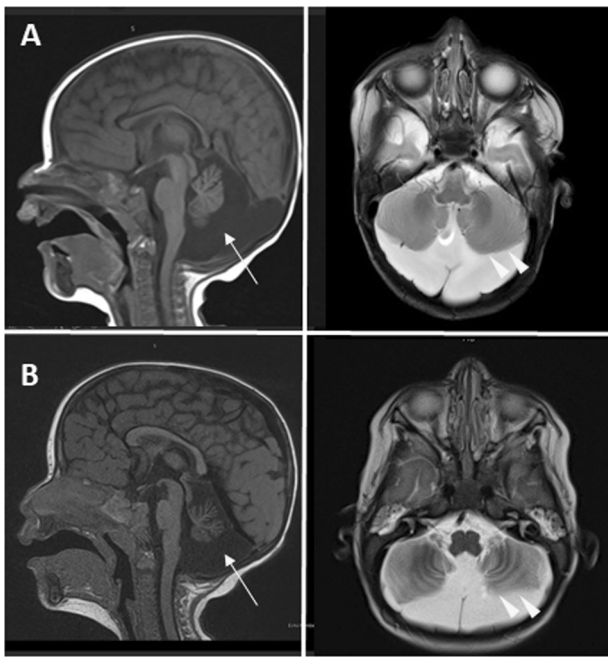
Brain magnetic resonance imaging (MRI) of affected individuals. Sagittal T1 and axial T2 views demonstrating enlarged CSF spaces, especially in the posterior fossa, with relatively small cerebellar hemispheres and vermis (yellow arrows and arrowheads). a Family 1, individual III-1 at 5 months of age. b Family 2, individual II-6 at 12 months of age
